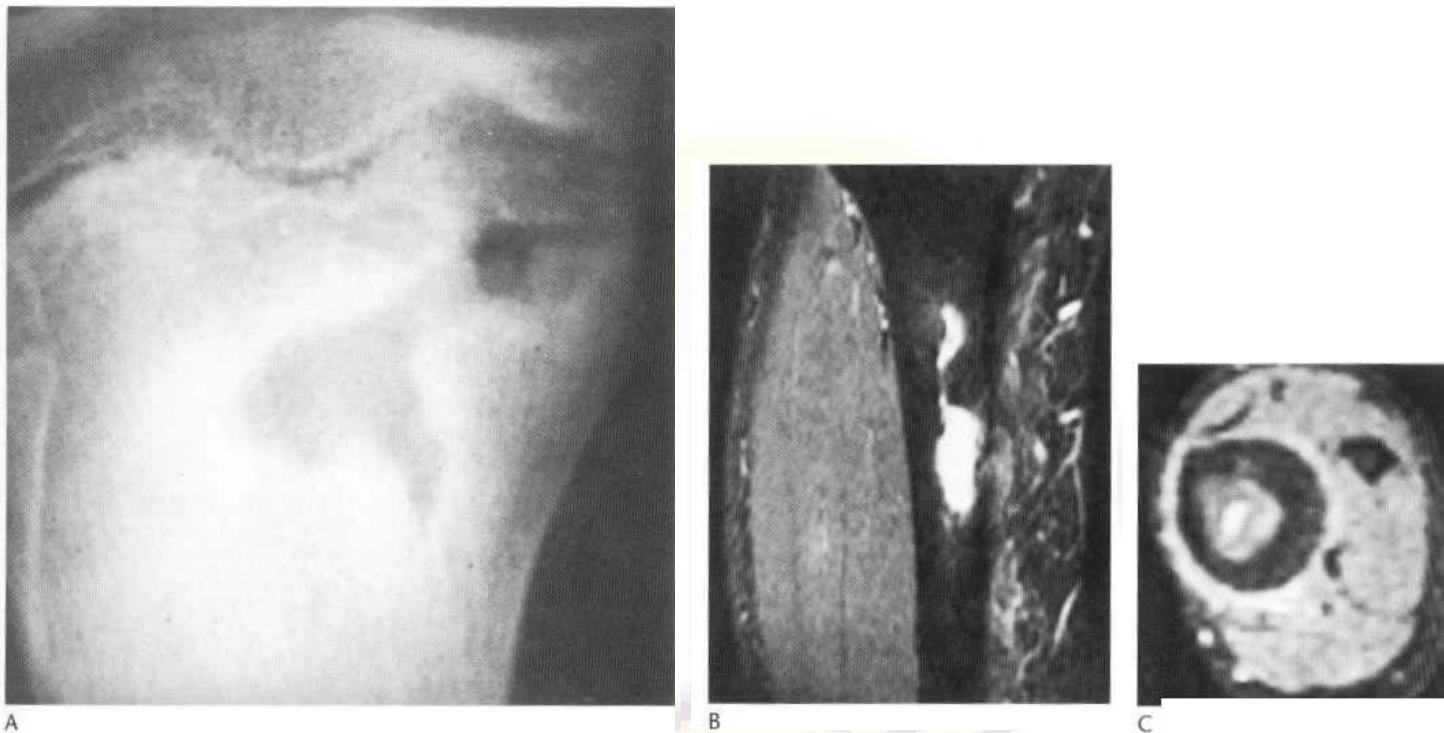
'Tunnelling' in osteomyelitis. (A) A finger-like process of osteomyelitic bone destruction extends from the main focus. This is tunnelling, which usually indicates the presence of chronic infection. (B) In another patient, the sagittal fat-suppression MR sequence shows a vertically orientated and fluid-filled cavity in the proximal tibia. It is well defined and has all the features of a chronic infective lesion. (C) The chronically thickened cortex together with the central fluid-filled cavity lying within the medulla are demonstrated on this axial fat-suppression MR image.
